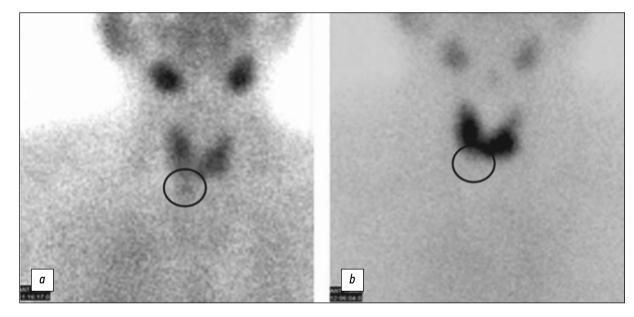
Dual-isotope scintigraphy: *a*, ^{99m}Tc-MIBI scintigraphy; *b*, ^{99m}Tc-TcO4 scintigraphy.
